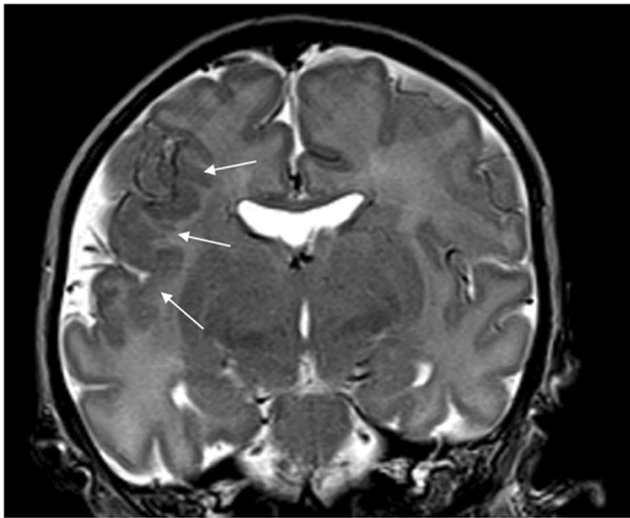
Case 4, a 14-day-old girl. T2-weighted coronal MR brain image shows perisylvian polymicrogyria (*arrow*)
